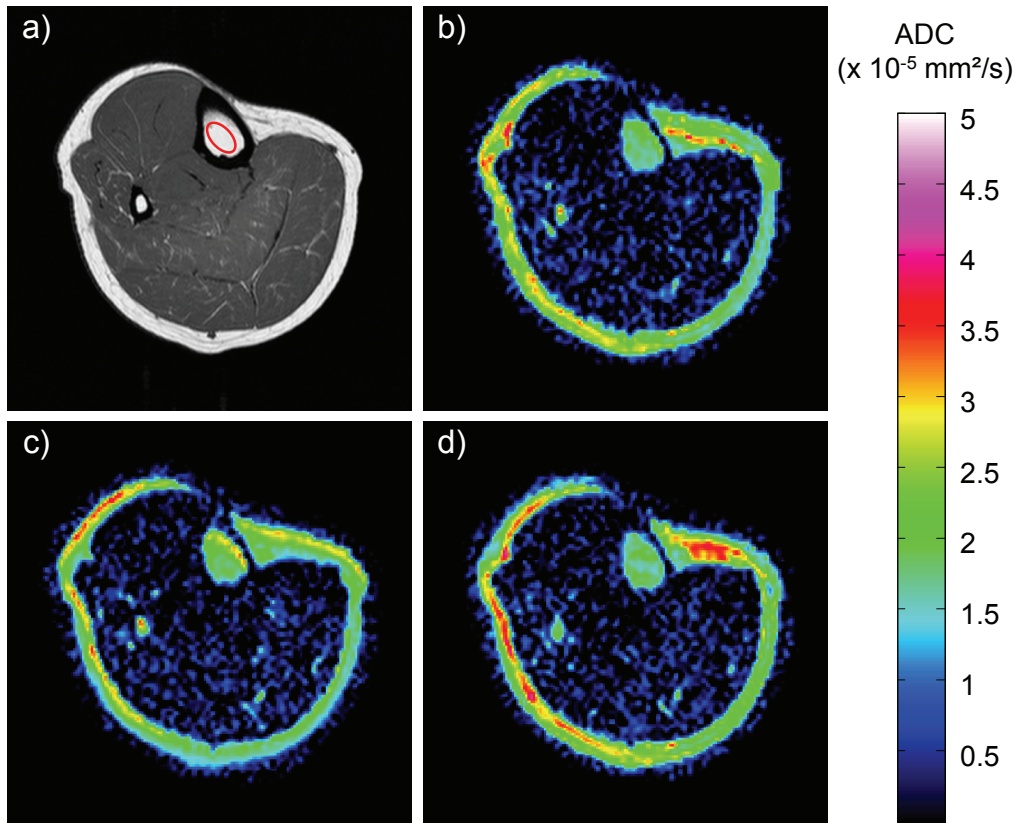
Transversal images of the lower leg of one volunteer: T1-weighted image for anatomical orientation a). ADC maps determined from the diffusion weighted images in left-right- b), anterior-posterior- c) and head-feet- direction d). The ROI for evaluation of the ADC within the tibial bone marrow is indicated by a red ellipse in Figure part a).
